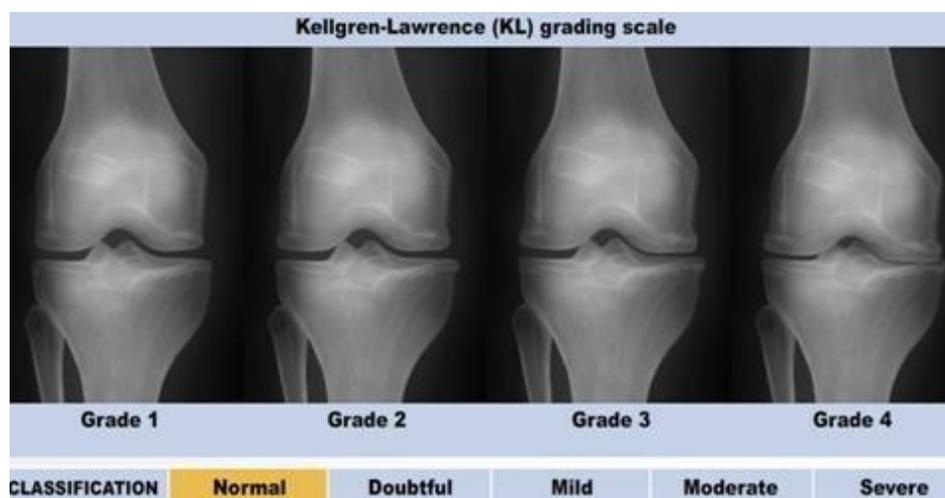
Kellgren and Lawrence classification system, radiographic characteristics of different stages in knee osteoarthritis
